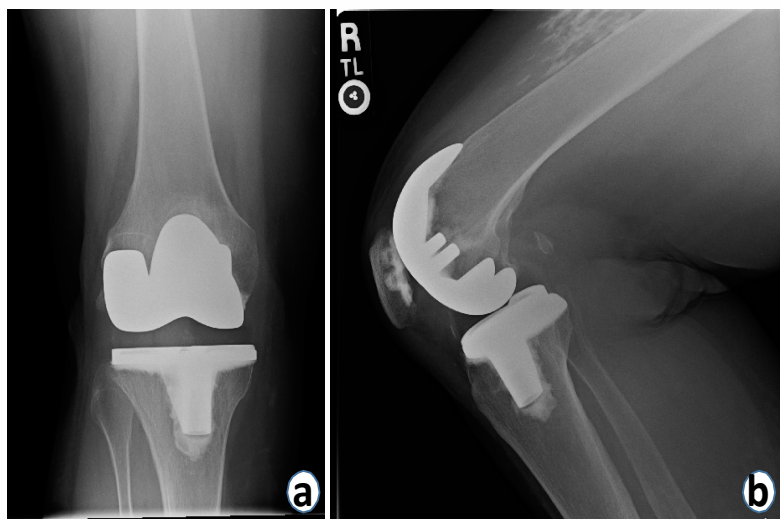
(a) Anteroposterior and (b) lateral radiographs of the right leg of a 73-year-old woman with calcified myonecrosis infiltrating the anterior compartment of the thigh.
